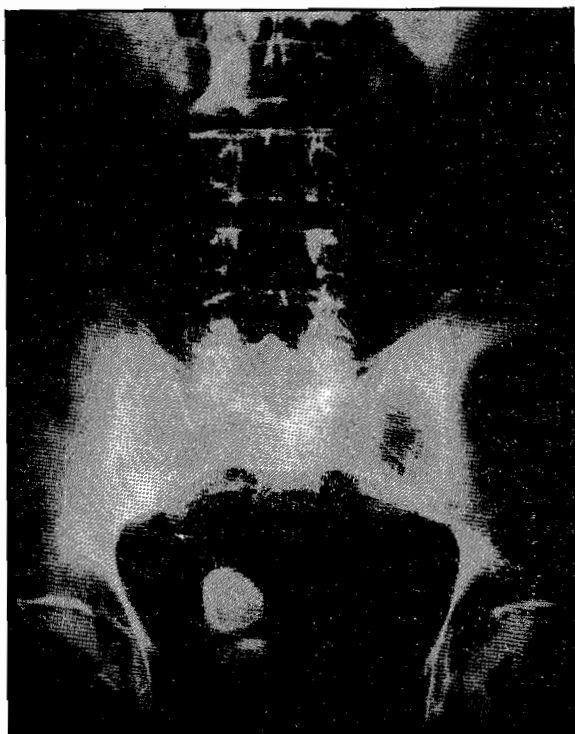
Plain radiograph showing two pouch stones. They were treated with lithoclast
